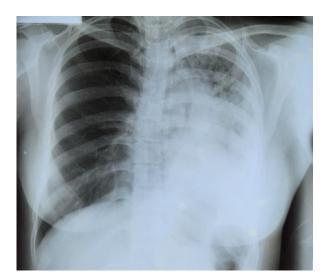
Chest Radiograph (2014). Active tuberculosis.
